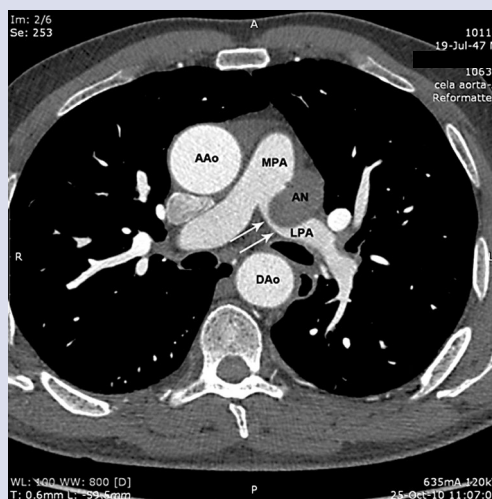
Multislice computed tomography of the thorax. Aneurysm (AN) of the ductus arteriosus compresses (double arrow) the left branch of the pulmonary artery (LPA); MPA — main pulmonary artery; AAo — ascending aorta; DAo — descending aorta
